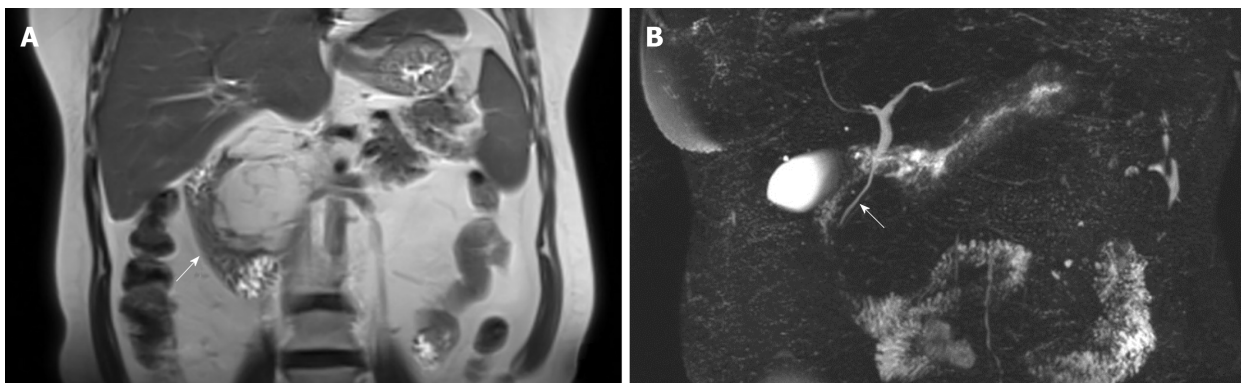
Coronal magnetic resonance scan and magnetic resonance cholangiopancreatography before treatment. A: Magnetic resonance imaging showed a fat-signal lobulated tumor compressing her duodenum (arrow); B: Magnetic resonance cholangiopancreatography demonstrated that there was no dilatation and stenosis in the intrahepatic bile duct and the pancreatic duct, but the middle and lower part of the common bile duct was partially compressed (arrow).
